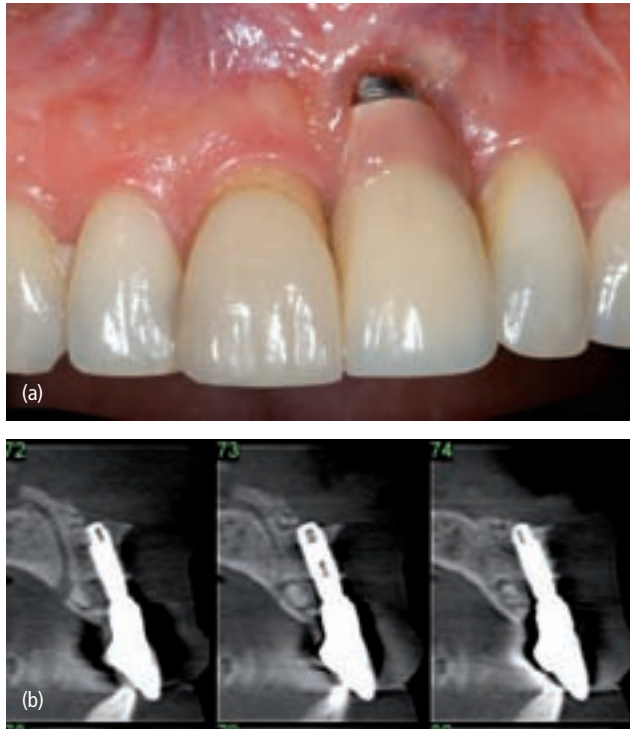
(a) A severe recession of the mucosa has occurred owing to a facial malposition of the implant in the upper left central incisor site (site 9). (b) Cone beam computed tomographic scan of the implant showing the facial malposition of the implant.
